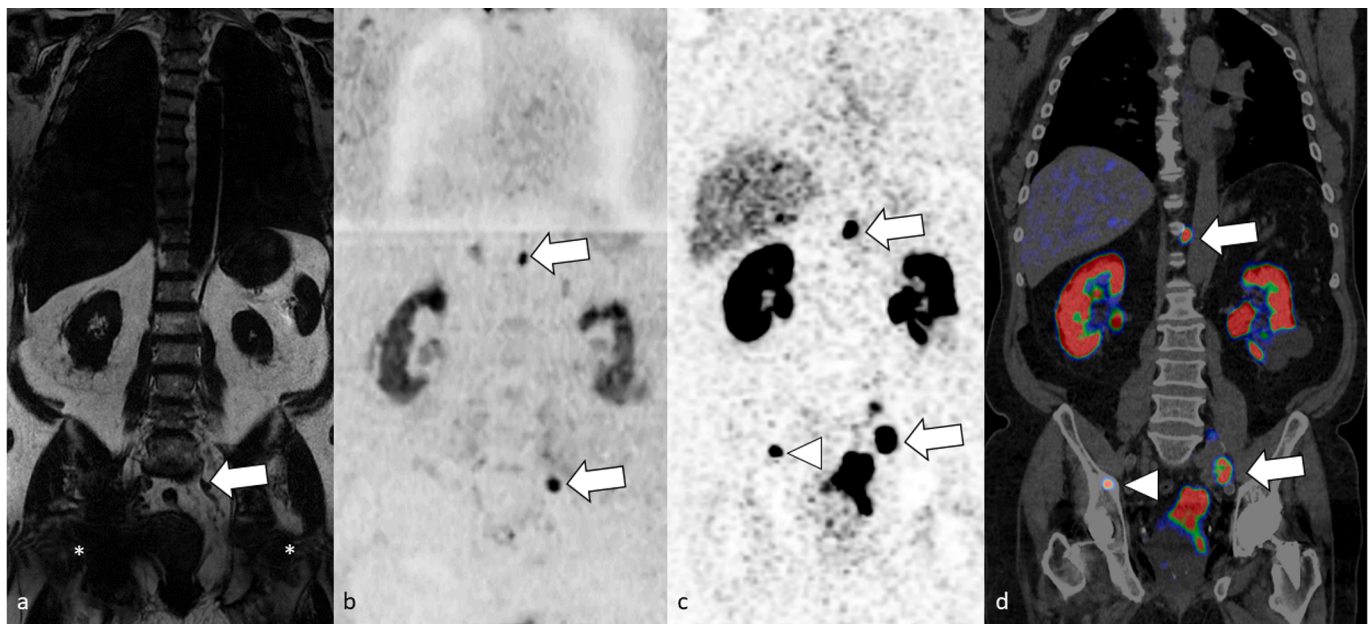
Discordant distant extension between fast “All-in-One” WB-MRI and ^{68}Ga -PSMA-PET/CT, in a 76-year-old man with high-risk PCa. Coronal WB-MRI T1 Dixon Fat only (a), and coronal reformatted DWIBS ($b = 1000 \text{ s/mm}^2$; inverted grayscale) showed vertebral bone lesion and left locoregional lymphnode metastasis (arrow) (b). Bilateral total hip replacement (*) was responsible for artefacts. ^{68}Ga -PSMA-PET/CT (c), and reformatted fused PET/CT showing one more 5 mm bone lesion of the right iliac bone not shown on WB-MRI due to total hip replacement (arrowhead) (c).
